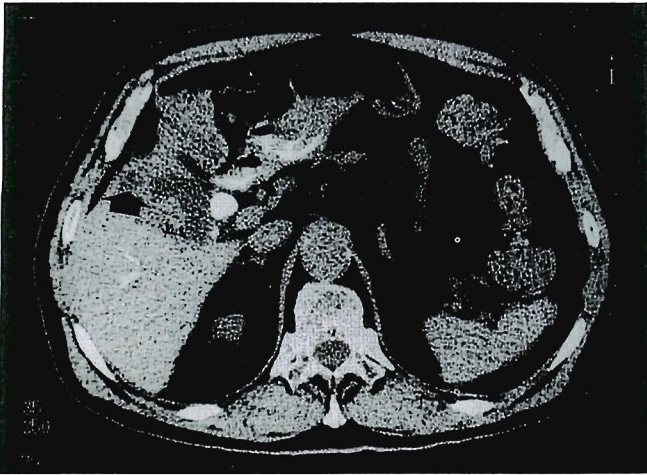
A CT scan revealing a low attenuation (arrow) area in the thickened gallbladder wall (Case 3).
